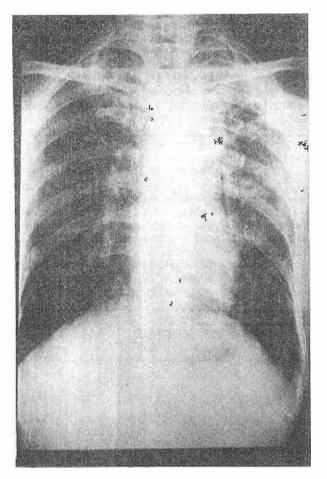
The Chest radiograph of Case 1 showing bilateral active Koch's lesion.
